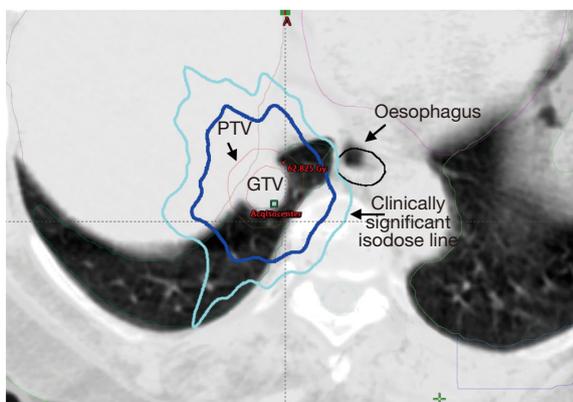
Example of CBCT in a patient undergoing lung SABR 60 Gy/5 fx—light blue represents the clinically significant isodose line. Esophagus should be positioned outside this critical isodose. SABR, stereotactic ablative body radiotherapy.
